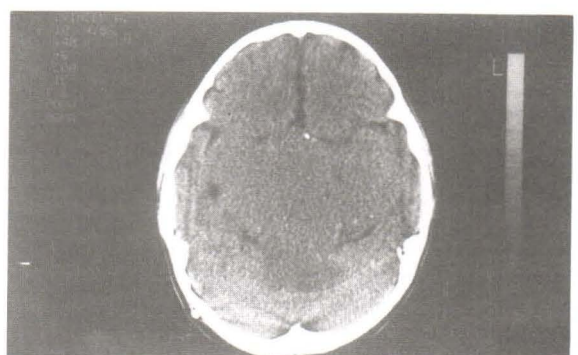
6 weeks after completion of radiotherapy : a brain CT scan demonstrating increased attenuation of mass as compared to previous study with no significant change in size.
